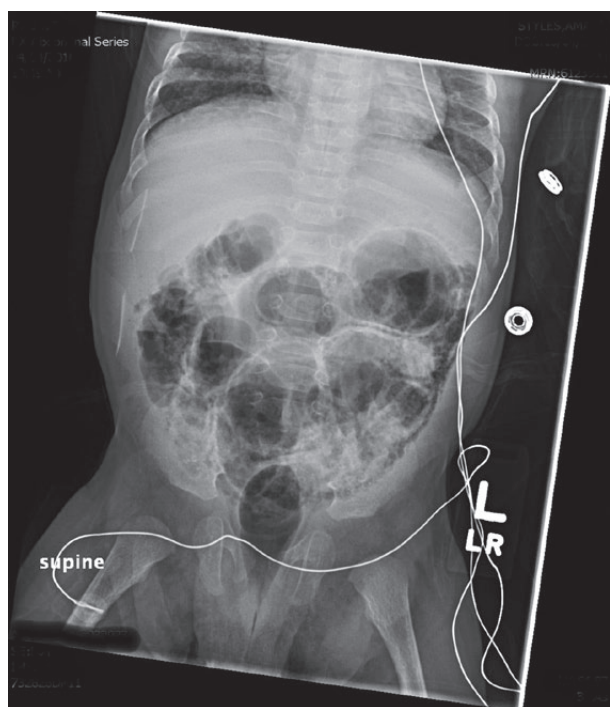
Abdominal x-ray shows dilated bowel loops and intramural air. Both linear and bubbly pneumatosis intestinalis were noted.
